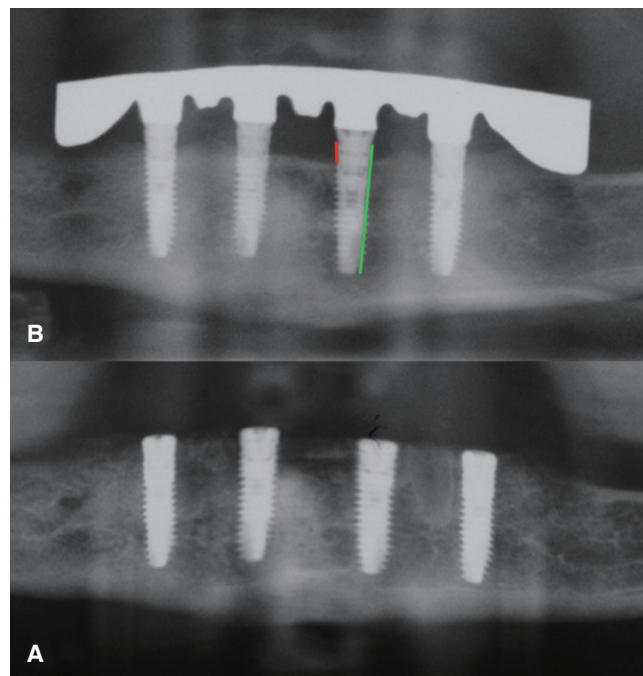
Measurement of radiographic bone loss. (A) Baseline after implant insertion, (B) After 5 years of clinical function. The implant length is marked for calibration (green line), and the highest bone loss at implant 032 (mesial site, red line) is also marked.
